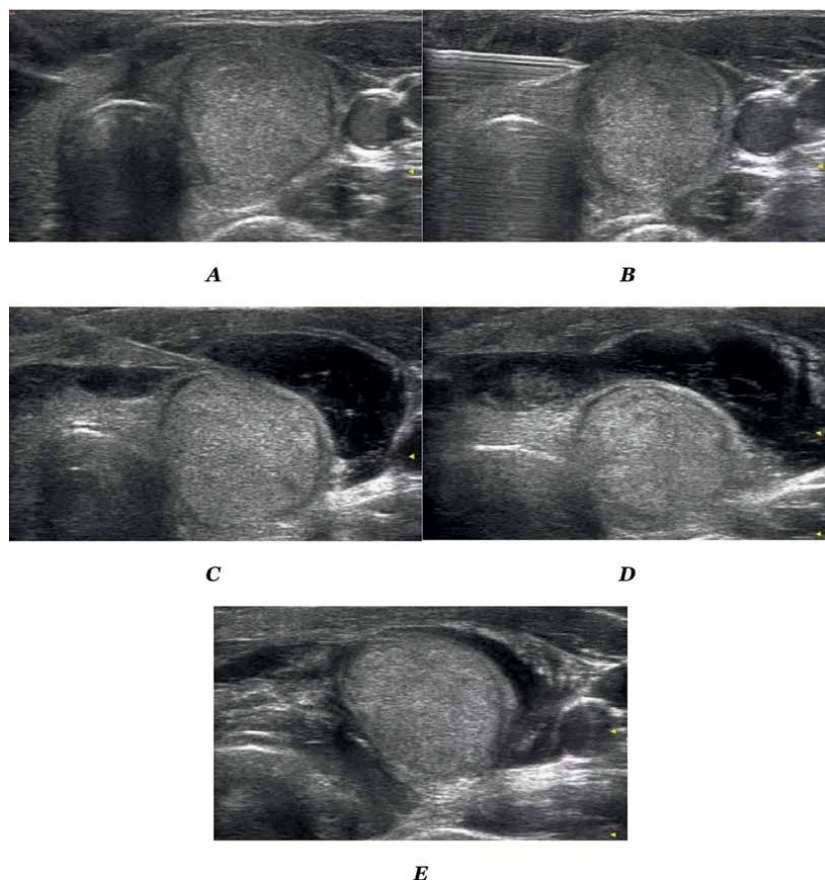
Conduction of liquid isolation method under ultrasound guidance. (A) shows the natural state of a thyroid nodule in the right lobe, it was located closely adjacent to the trachea, right common carotid artery, strap muscle, and collilongus. (B) shows the introducing of fine needle and the tip of the needle reaches at the sternothyroid muscle. (C) shows an anechoic area of saline (isolation zone) appeared in the lateral space of thyroid. (D) shows the isolation zone branched out from the lateral interspace to the anterior interspace of thyroid. (E) shows the isolation zone developed in the medial interspace of thyroid to separate the thyroid nodule away from trachea.
